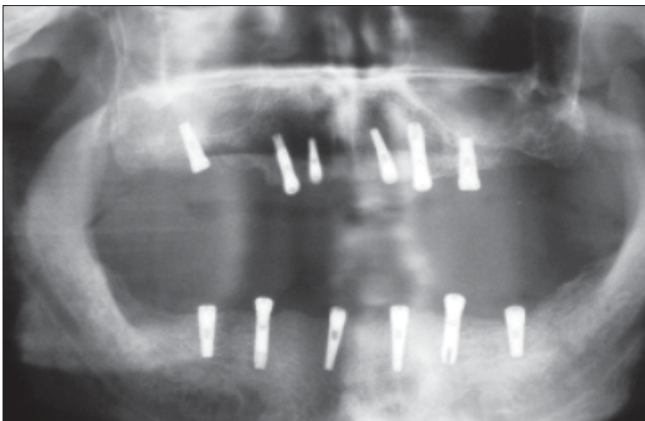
Postimplant placement panoramic radiograph
